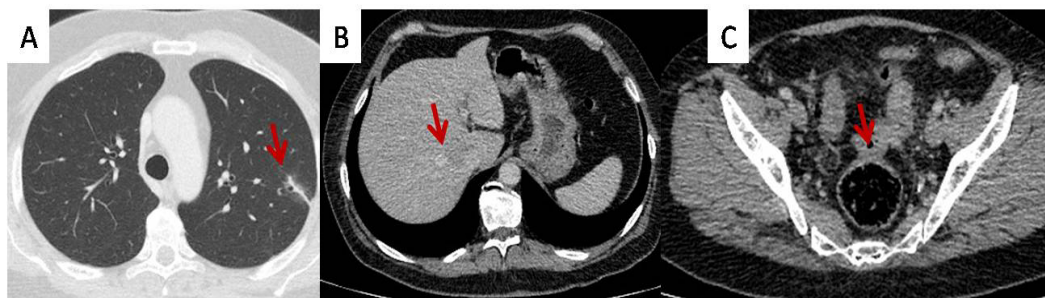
Post-treatment; A: Thorax CT scan: The abscess was completely healed but some fibrotic lung changes were seen at that area of left lung. B: Upper Abdominal CT scan: There were no sign of abscess in liver. C: Lower Abdominal CT scan: The sigmoid colon abscess.
